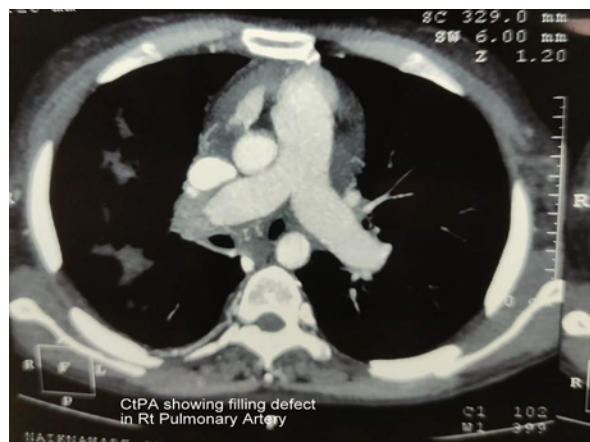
CT Pulmonary Angiography Showing Filling Defect In Right Main Pulmonary Artery
